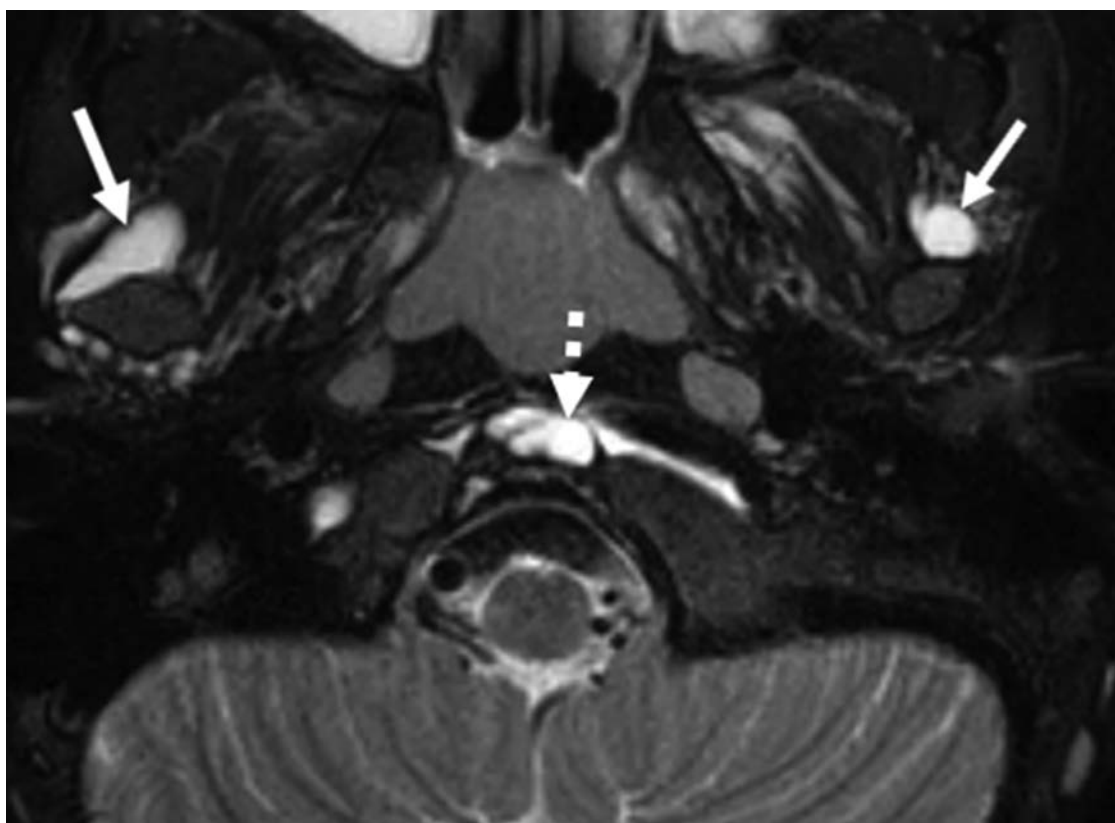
MRI obtained when the child was 3 years old. Axial T2-weighted MRI image shows cystic lesions at the atlanto-dens articulation (dashed arrow) and adjacent to the bilateral TMJs (solid arrows). The lesions are bright signal intensity on this T2-weighted image and showed only rim enhancement on postcontrast images (not shown). MRI: magnetic resonance imaging; TMJ: temporomandibular joint.
